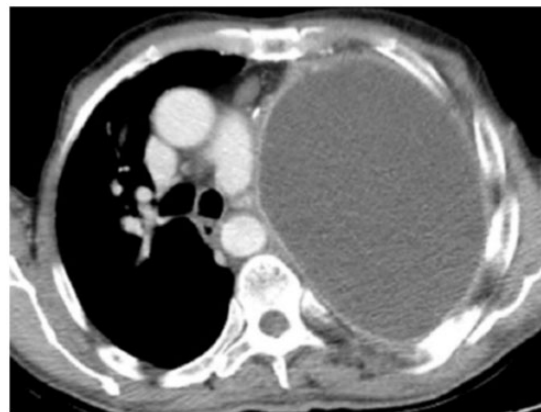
Thoracic axial computed tomography showing a left postpneumonectomy empyema.
